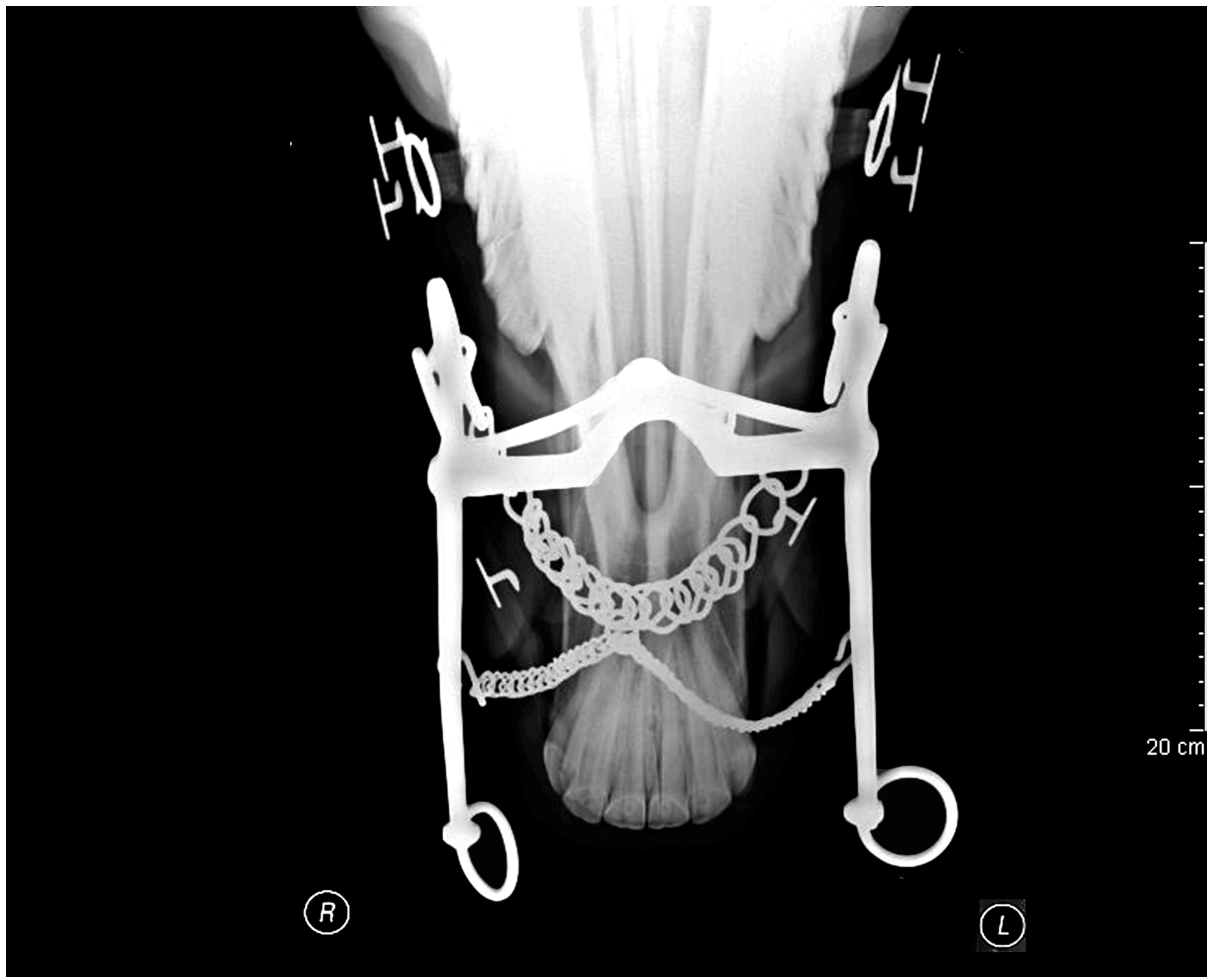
Dorso-ventral radiograph of a double bridle *in situ*. Two bits and a chain are mandated by the FEI for international dressage competitions and for national competitions at advanced levels.
